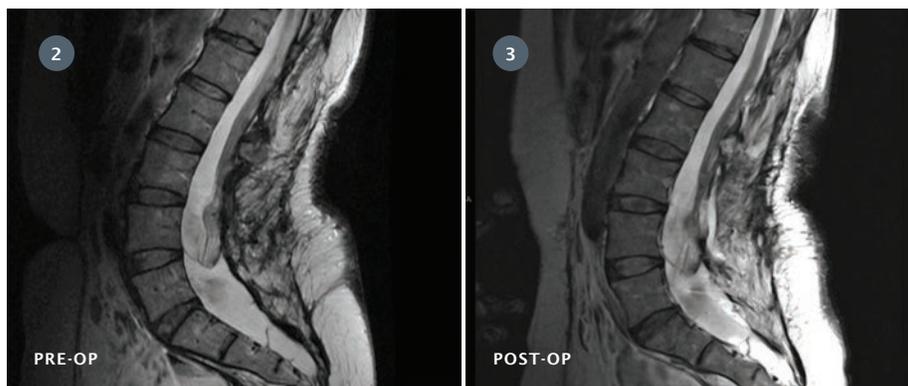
Shows an MRI of the patient prior to surgery.
